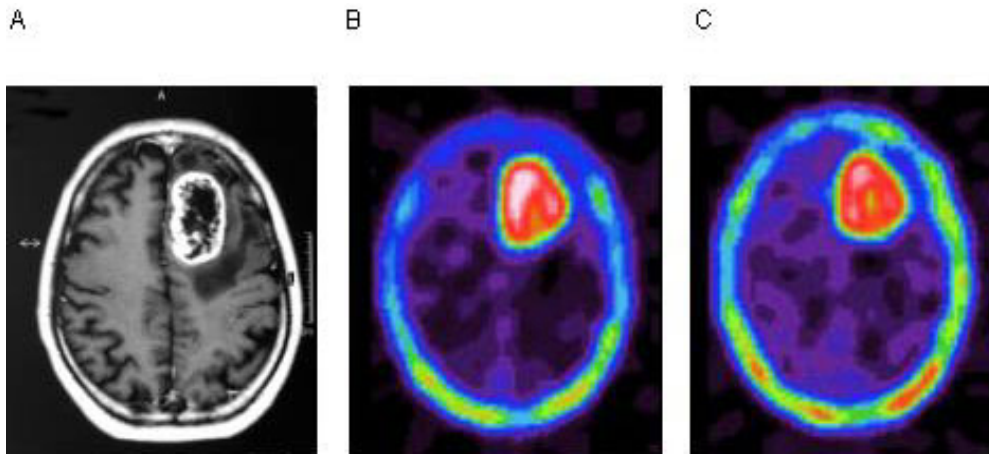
A 56-year-old man with glioblastoma (grade 4) in the left frontal lobe. MR image before therapy shows a ring-like well-enhanced lesion on gadolinium contrast-enhanced T1-weighted image (Gd-T1WI) (A). Intense tumor uptake with high T/N ratios (early: 9.88, delayed: 6.25) was seen on both the early (B) and the delayed (C) ^{201}Tl -SPECT images. Total tumor resection and postoperative external beam irradiation (total 50 Gy) were performed, but this patient died of related disease 10 months after radiotherapy.
